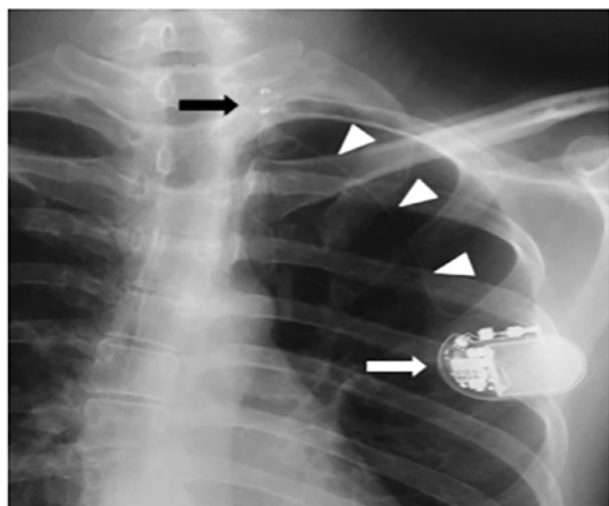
Lateral neck and chest x-ray showing the position of an implanted XN stimulator
